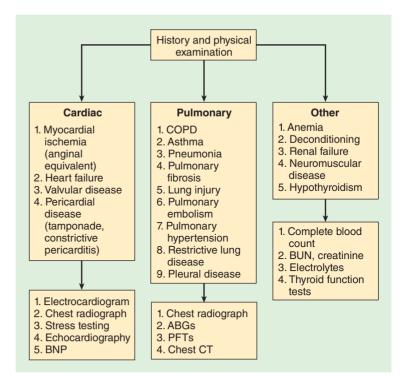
Evaluation of dyspnea. ABGs, arterial blood gases; BNP, brain natriuretic peptide; BUN, blood urea nitrogen; COPD, chronic obstructive pulmonary disease; CT, computed tomography; PFTs, pulmonary function tests. (Reproduced, with permission, from Sweitzer BJ, Smetana GW: Identification and evaluation of the patient with lung disease. Anesthesiol Clin 2009:27:673.)
